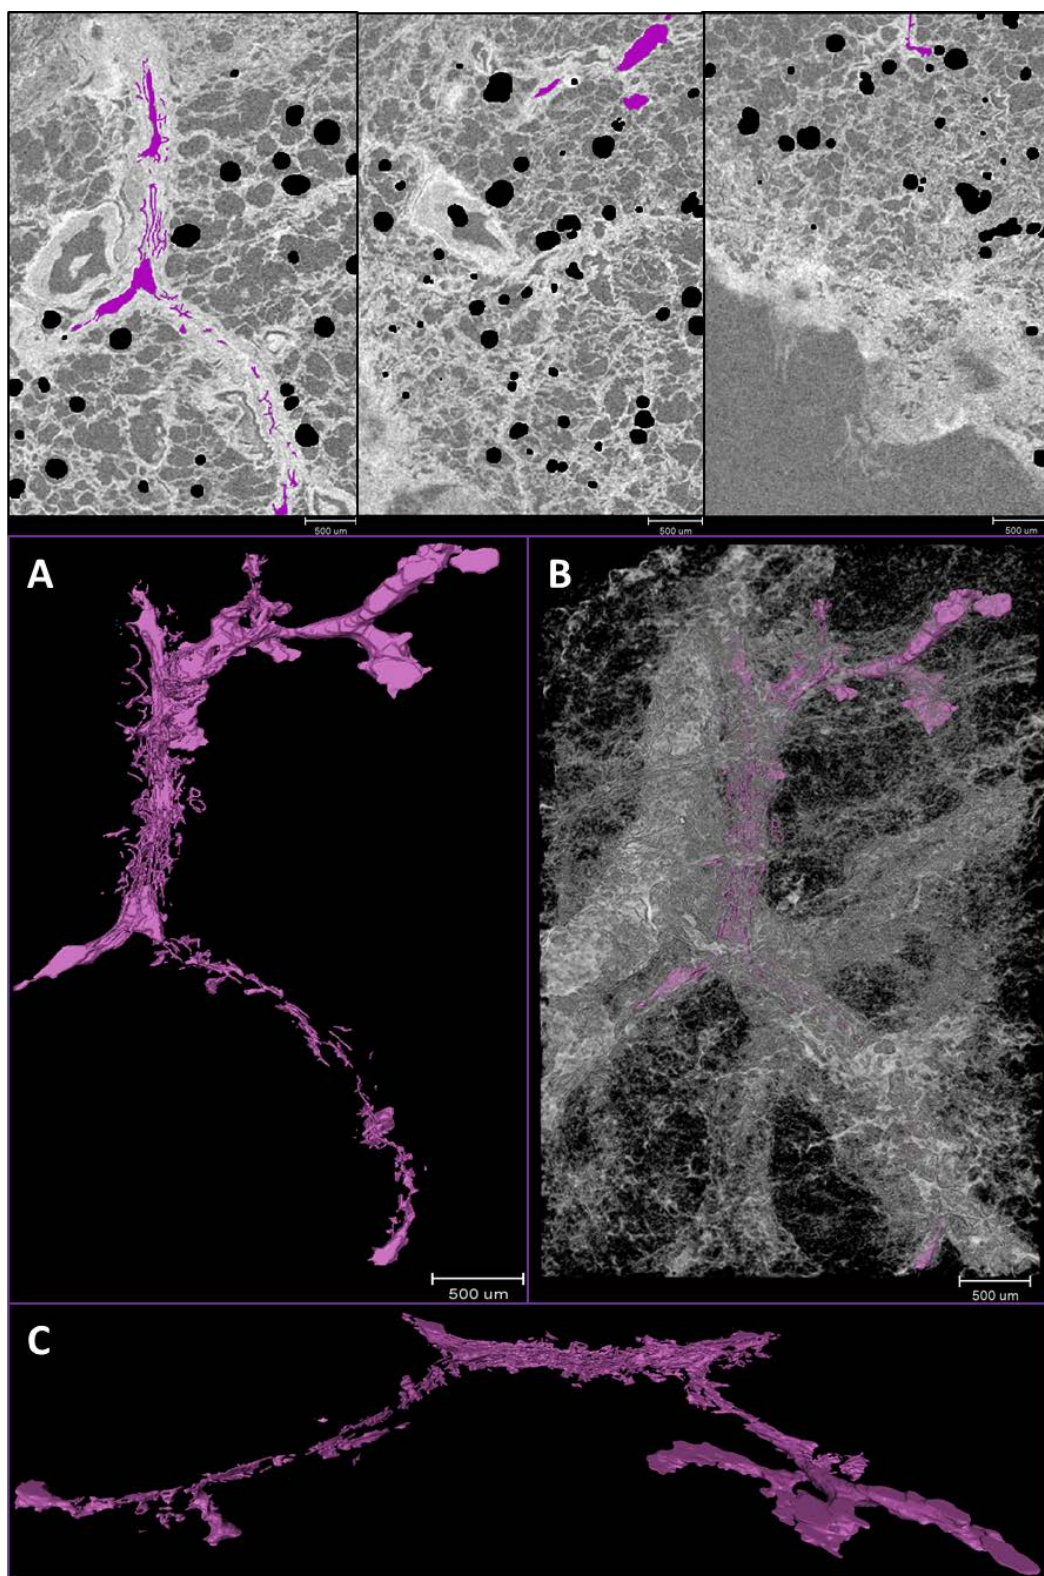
Manual airway lumen segmentation visualised in 2D and 3D. The upper panels show representative  $\mu$ CT slices through the volume with the airway lumen segmented (purple). The lower panels show the manual lumen segmentation as a 3D surface render. This was visualised independently of the  $\mu$ CT volume (A and C) and also within  $\mu$ CT volume rendering (B).
